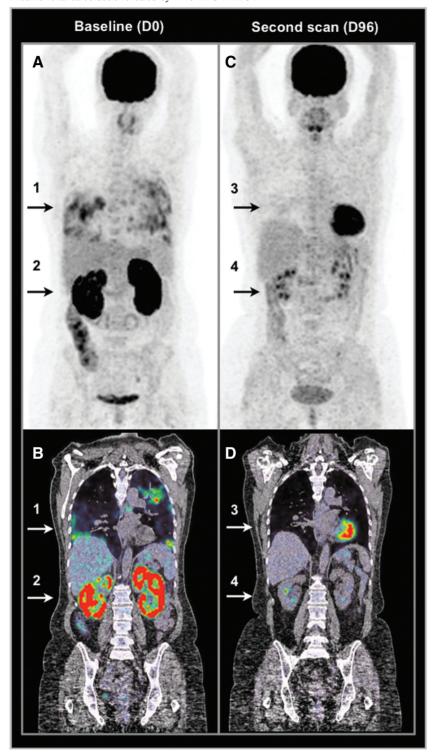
Coronal slices of F-18 FDG PET (A and C) and fused PET/CT (B and D) tomography of a 61-year-old non-smoking woman presenting with low-grade fever of unknown origin. The figure compares two acquisitions performed respectively at Day 0 (baseline, A and B) and 96 days later, after the initiation of a glucocorticoid systemic therapy (second scan, C and D).
